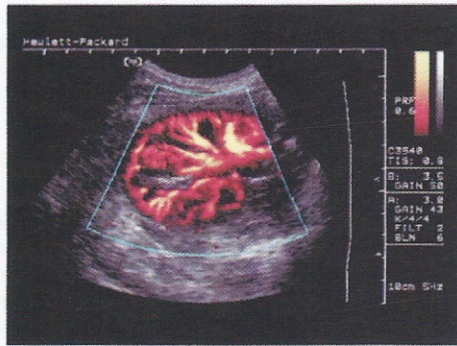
Renal flow perfusion displayed in power Doppler mode.
